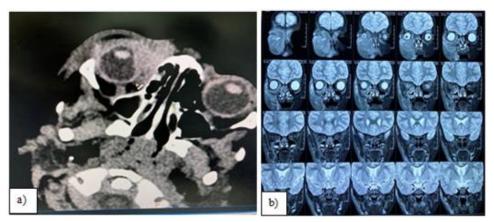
Imaging studies a) CT scan, axial sections b) MRI coronal sections, revealing mass in inferonasal orbit and extending to maxillary region
